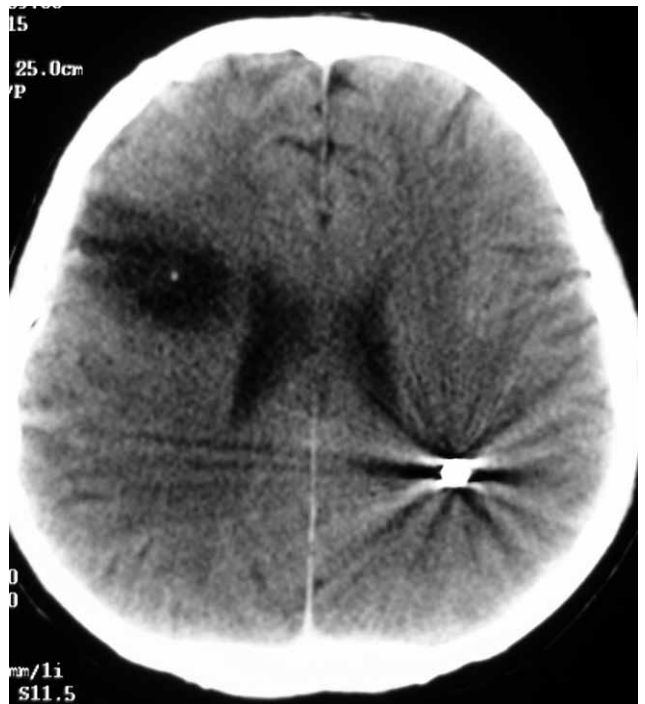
CT scan of the third case shows metallic screw and encephalomalacic area.
